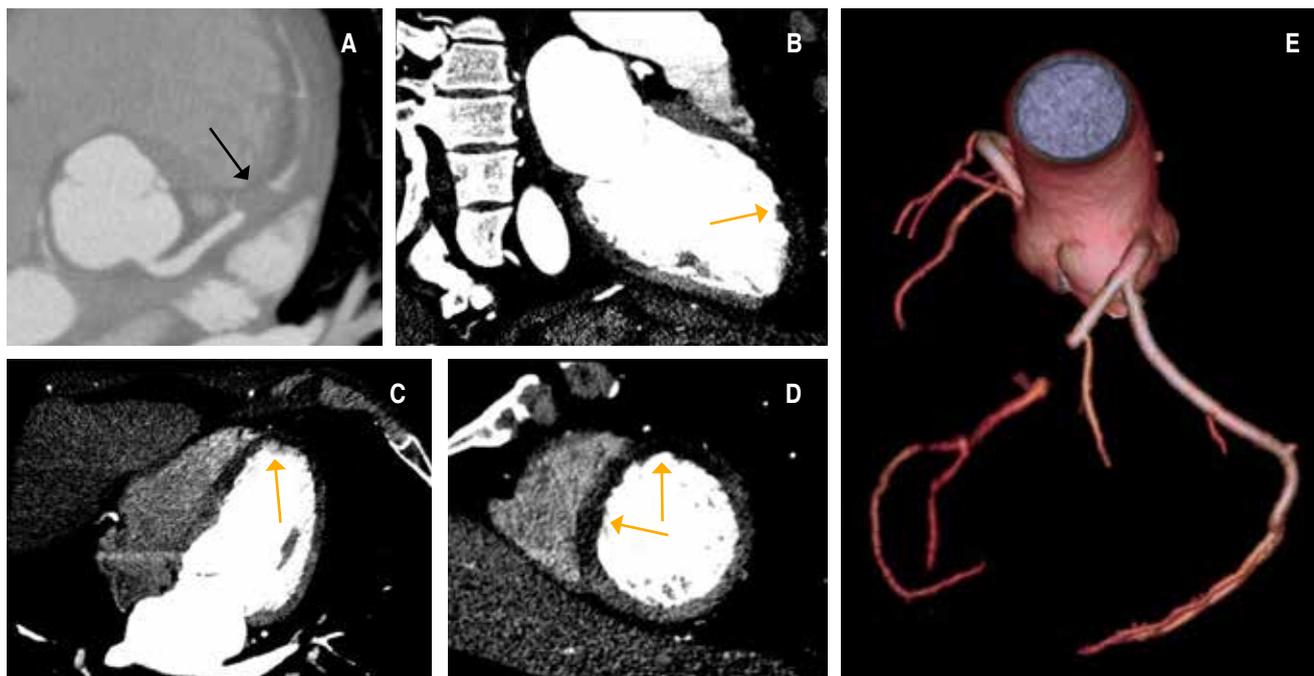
Coronary computed tomography angiography. A) Non-calcified occlusive plaque in the proximal third of the left anterior descending artery (arrow). B) Two-chamber view: perfusion defect in the anterior wall during the stress test (arrow). C) Four-chamber view: perfusion defect in the septal and lateral wall at middle and apical segments (arrow). D) Two-chamber view: perfusion defect in the anterior, anteroseptal and inferoseptal surfaces at the mid-segment (arrow). E) 3D reconstruction of coronary arteries: Total occlusion of the left anterior descending artery.
